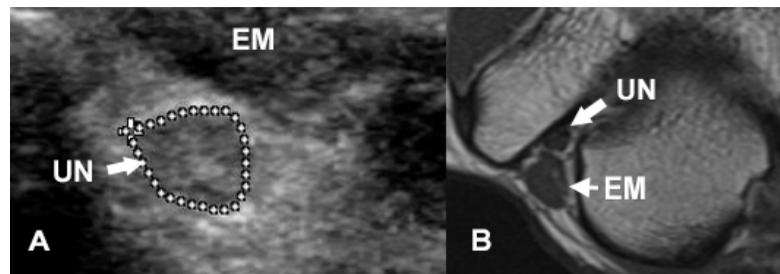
ultrasonography (A) and MRI (B) showing relation of ulnar nerve (UN) and epitrochleoanconeus muscle (EM)
